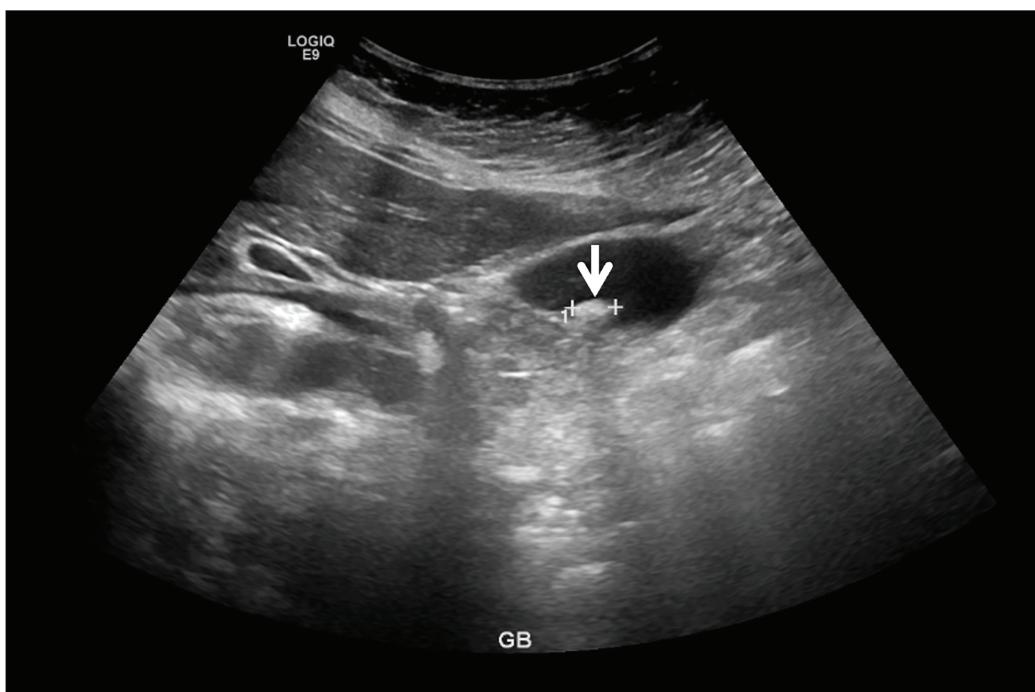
Ultrasonographic image of the gallbladder demonstrating a hyperechoic calculus (arrow) with posterior acoustic shadowing, consistent with gallstones.
